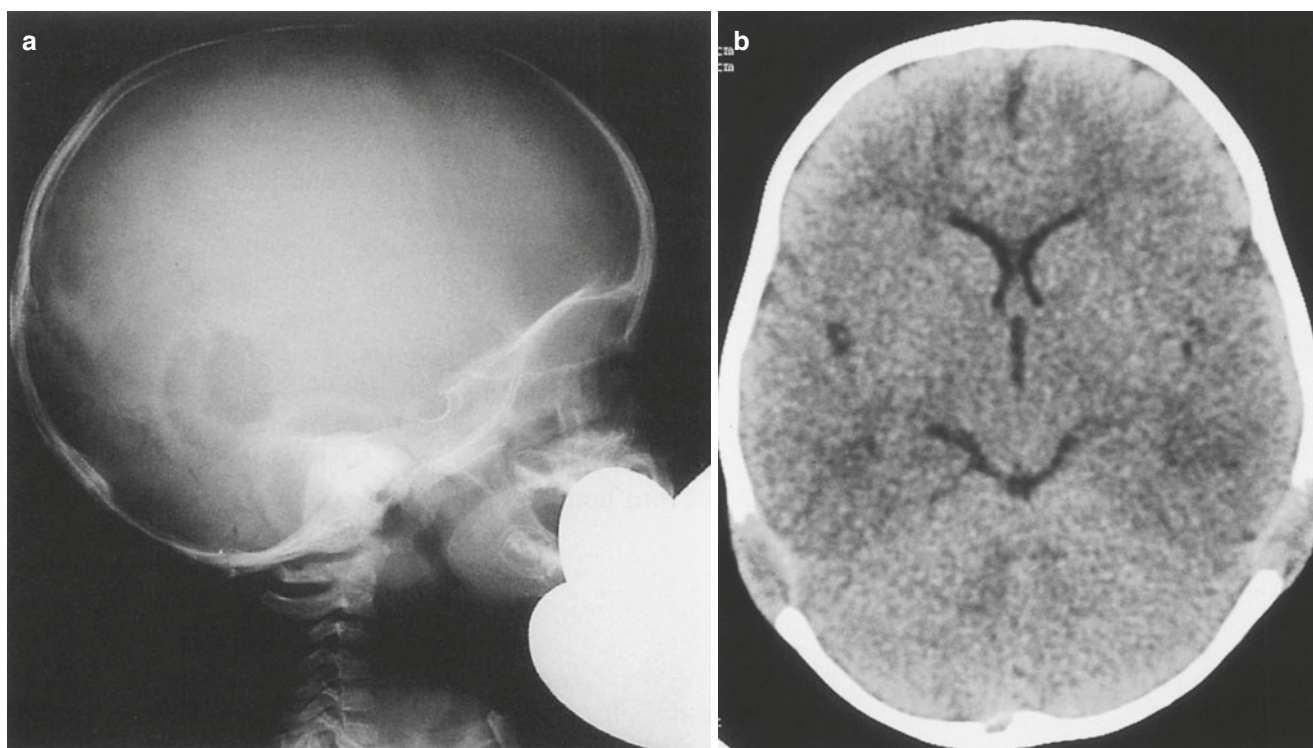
(a) Plain x-ray of skull showing punched out lesion of histiocytosis on both sides. (b) CT scan of the same patient
